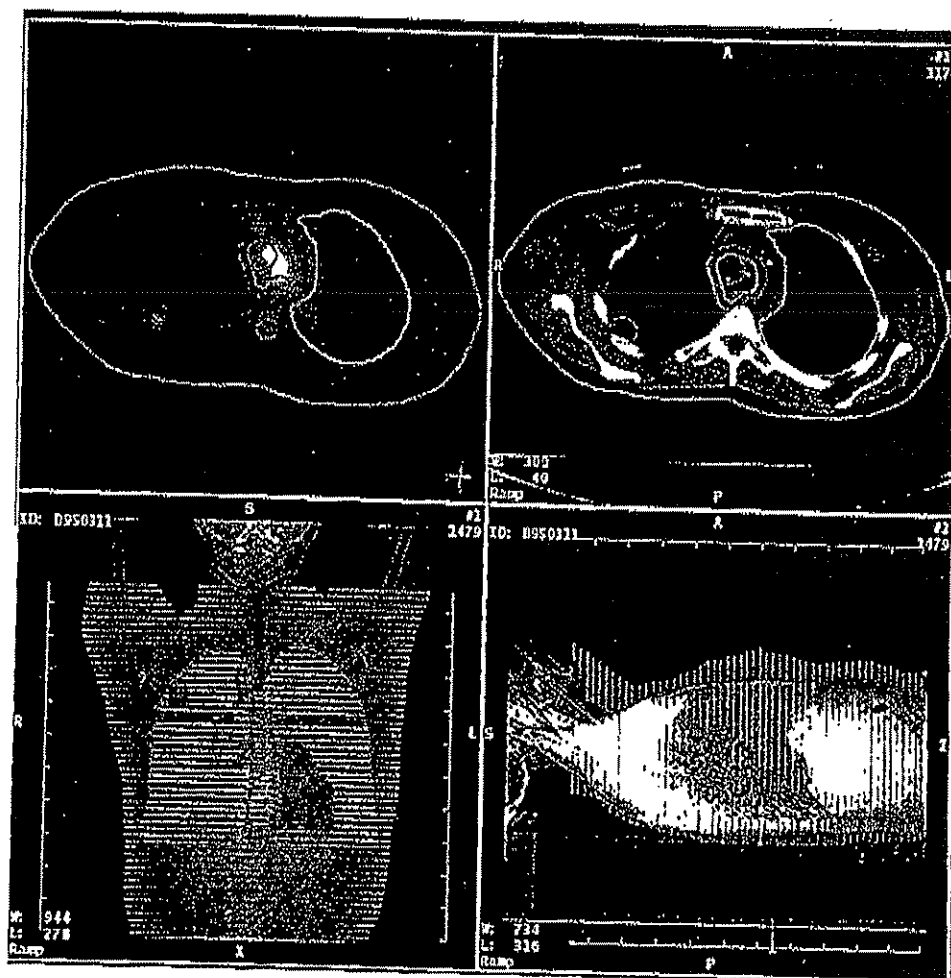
3DTPS software for contouring target volumes and organs at risk (image segmentation) continues to be improved, but is still not automated to the extent needed for IGRT. CT data are displayed and contours are drawn by the radiation oncologist around the tumor/target volumes, and organs at risk on a slice-by-slice basis, as seen in the upper right panel. At the same time, planar images from both anterior-posterior and lateral projections are displayed in the bottom right and left panels. The upper left panel shows PET scan data with overlying contours after image registration with the CT data. Continued development in automated image segmentation and image fusion (deformable registration) software should remain a high priority for the field.
